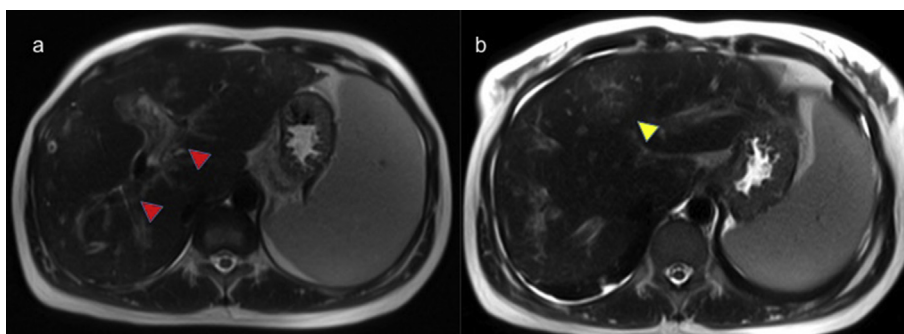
Liver MRI (A, B). Axial T2w SS-FSE sequence MR images showed bands with high signal intensity, keeping with extensive periportal fibrosis (A; red arrowheads) and a pseudonodular lesion with high-intermediate signal intensity in the periportal space (B; yellow arrowhead).
